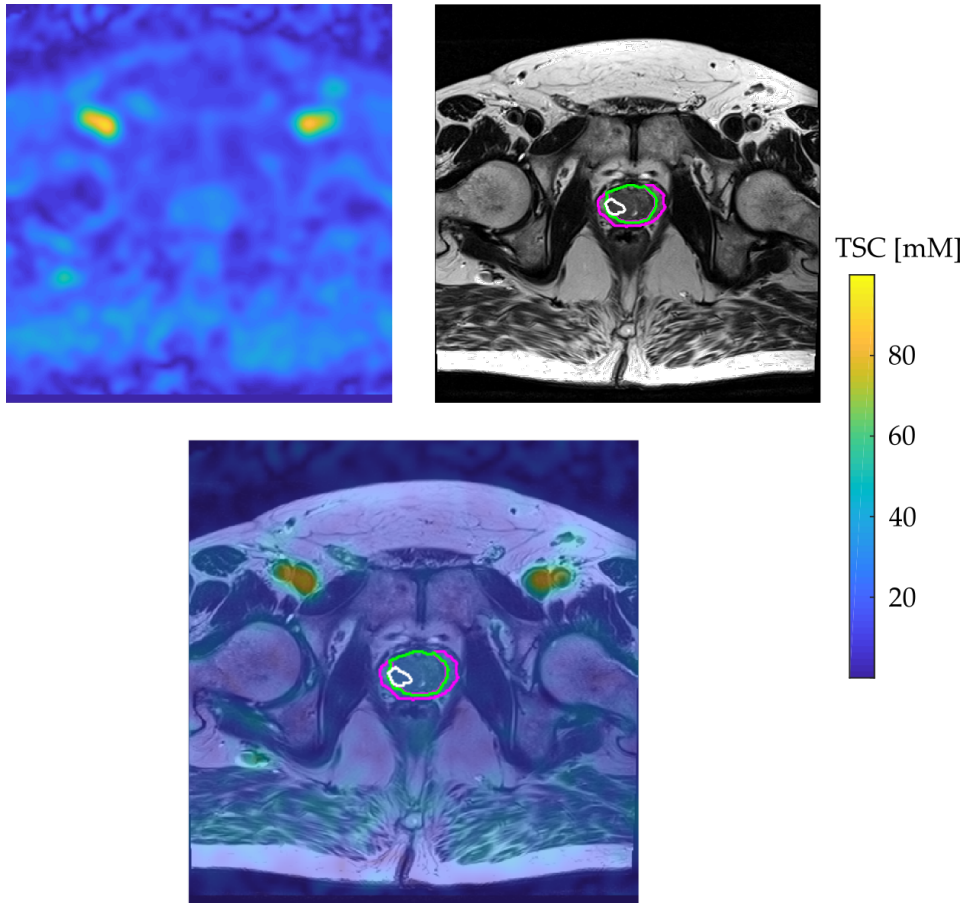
One transverse slice of the co-registered and quantified  $^{23}\text{Na}$  MR image and the T2 TSE MR image with the segmentation of PZ, TZ, and one lesion within the TZ (top), and the overlay of both images, including the segmented regions (bottom).
